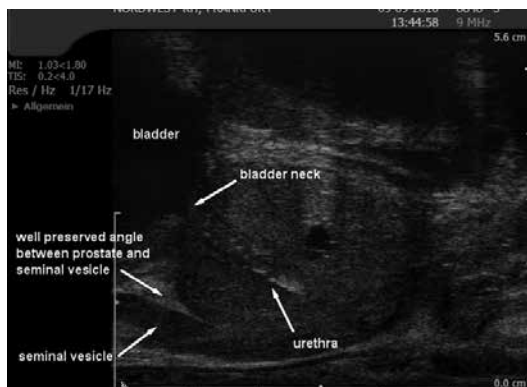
Ultrasound of the gross anatomy of the prostate demonstrated on TRUS (Courtesy: S. Hieronymi)
